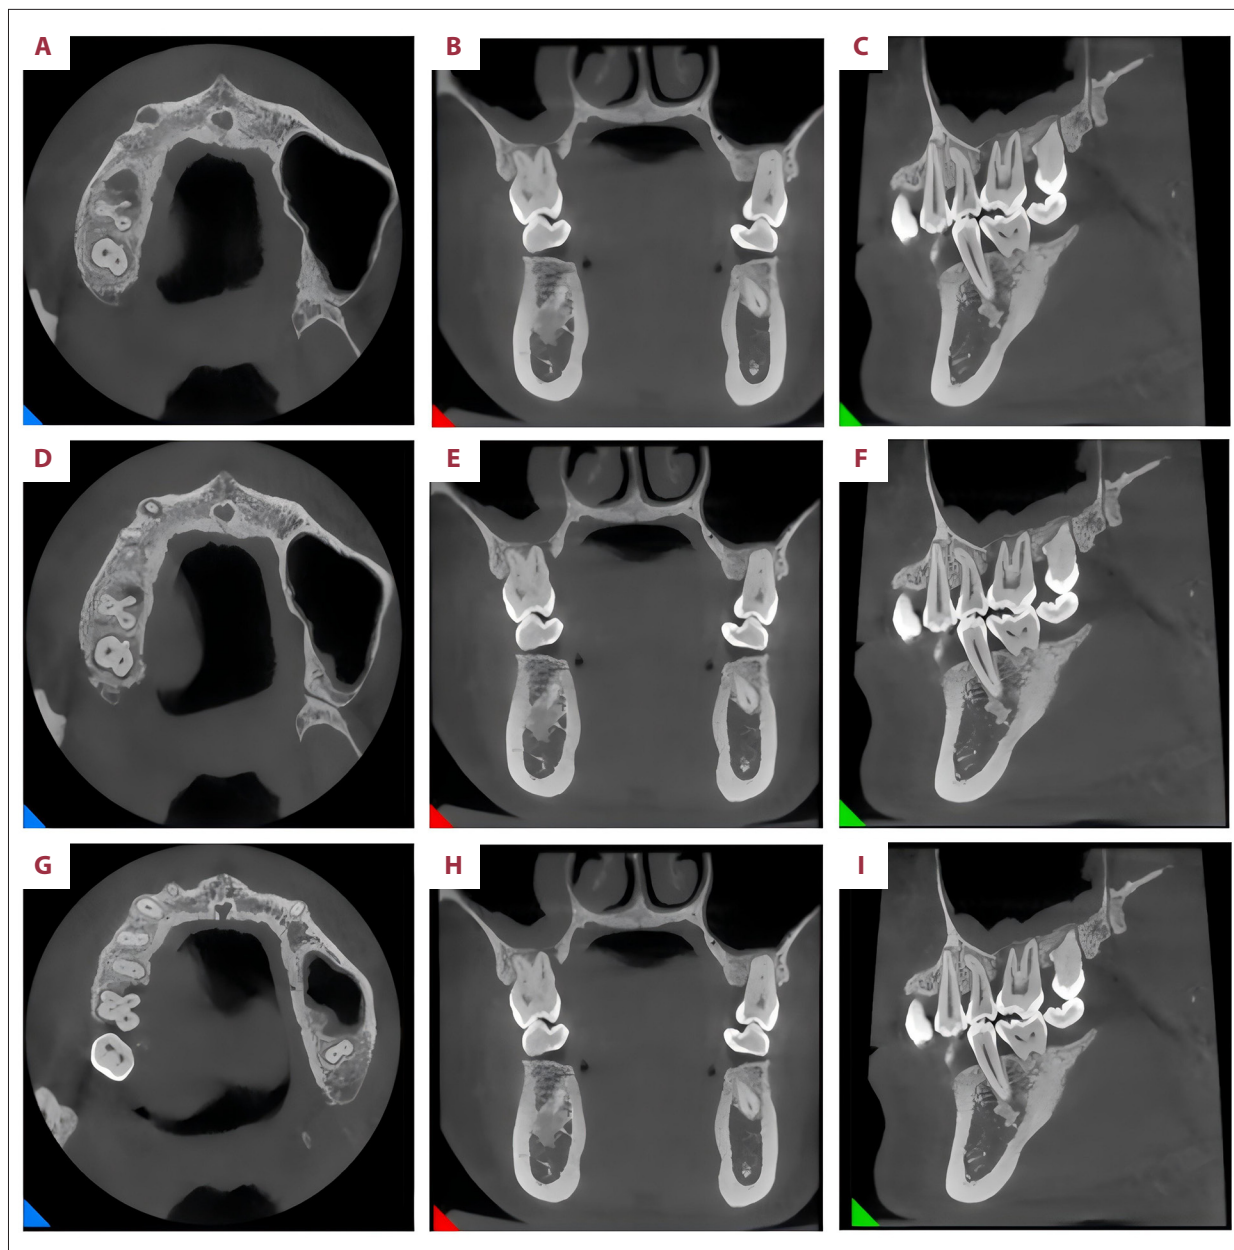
The CBCT imaging of the right maxillary first molar before treatment (A-C: images of the apical third of the root, D-F: images of the middle third of the root, G-I: images of the cervical third of the root).
